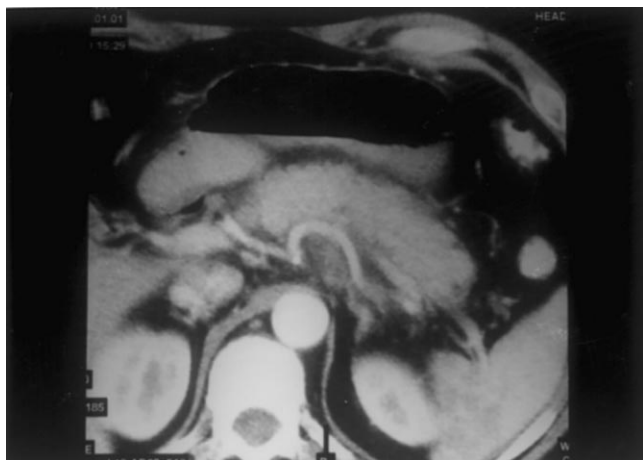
Acute pancreatitis (mild form). Arterial phase spiral CT. Diffuse enlargement of pancreas without fluid accumulation.
